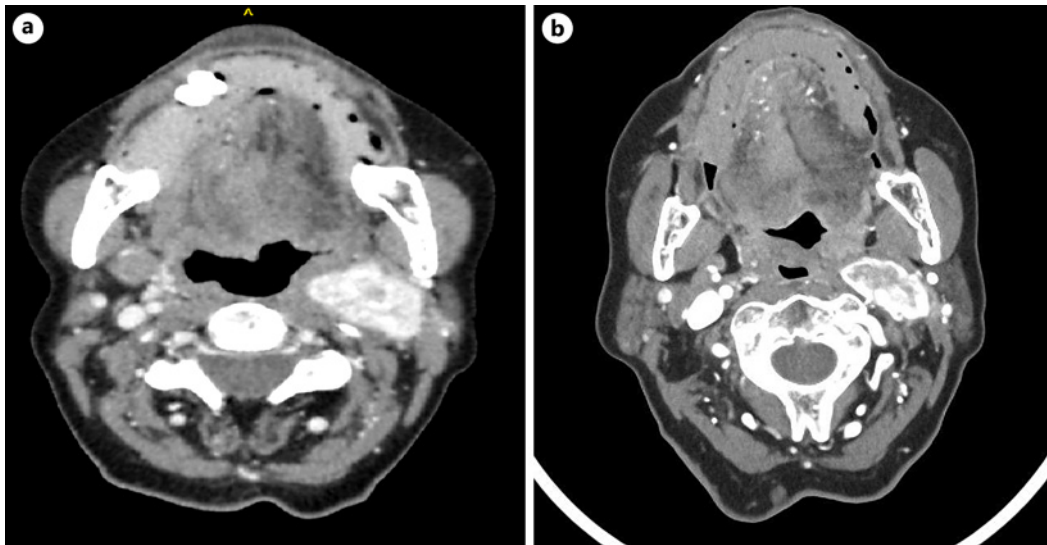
a CT of the PGL after ending the radionuclide therapy in January 2018 that shows a decrease in tumor size. b Last CT in May 2024 after 6 years of ending the radionuclide therapy that shows a stability of the tumor.
